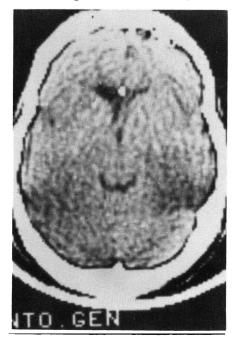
CT scan showing small ventricles, minor ventricular asymmetry and a well placed ventricular shunt tip.
